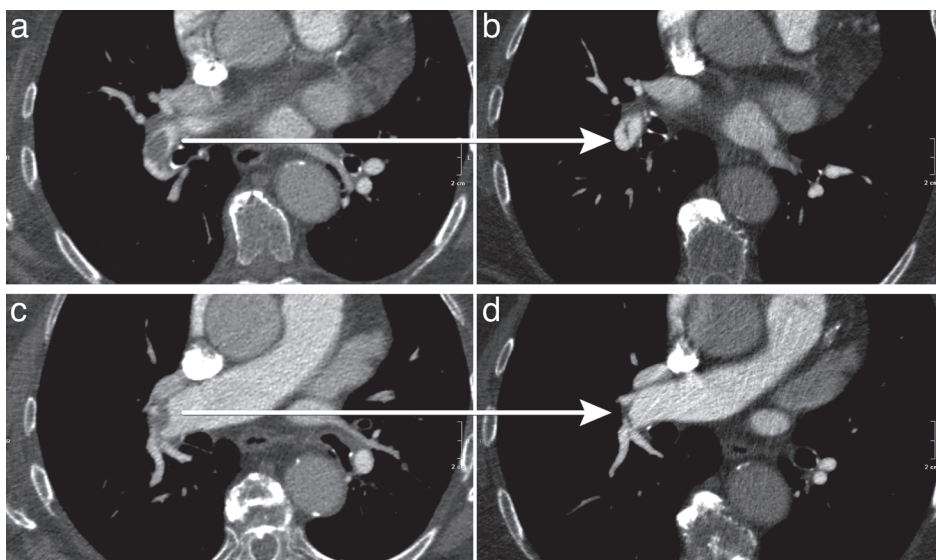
79-year old female presenting with acute dyspnea on exertion. Computed tomography images, axial orientation. Acute pulmonary embolism in right lung interlobar pulmonary artery (a, c). After six months of anticoagulant treatment (b, d), note presence of band or web in interlobar pulmonary artery, indicating incomplete resolution of the emboli.
